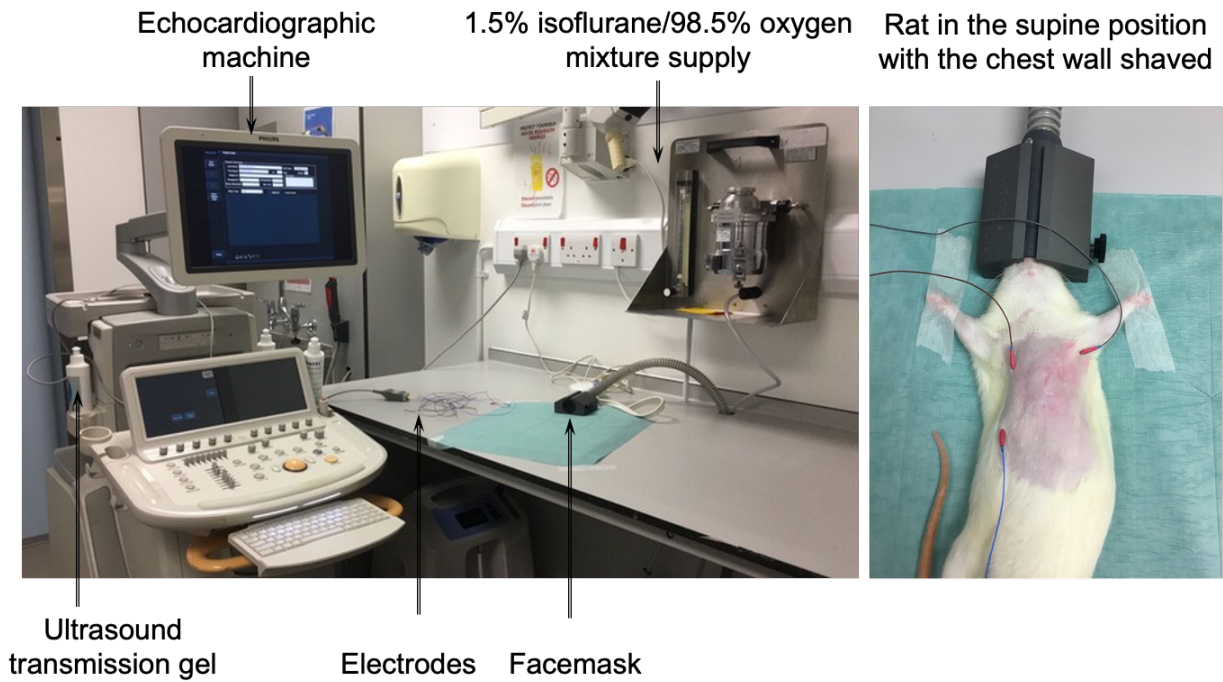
Echocardiography set-up.
